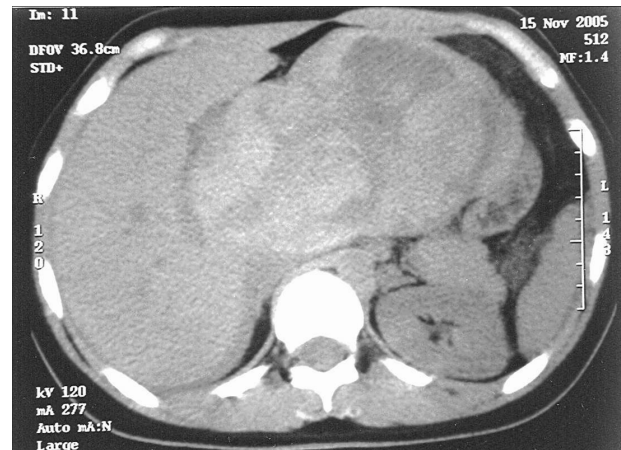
CT scan showing a large, heterogeneous and capsulated tumor.
